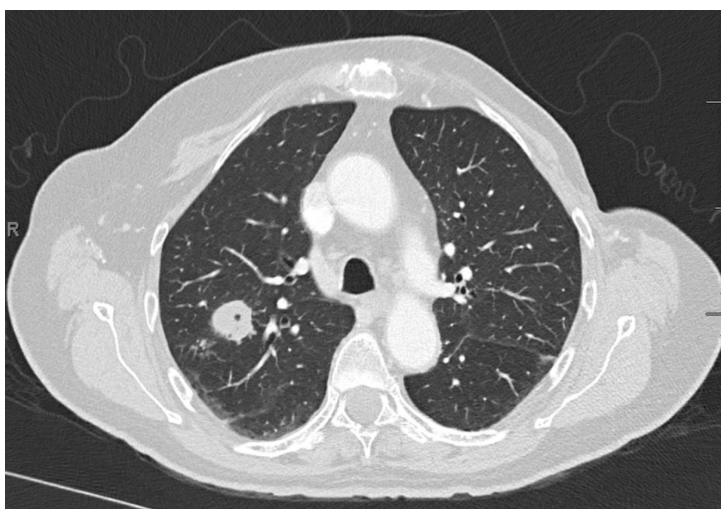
76 yo woman with 2 cm RUL nodule found on CT chest angiogram. This finding was described as a possible bronchocele.
